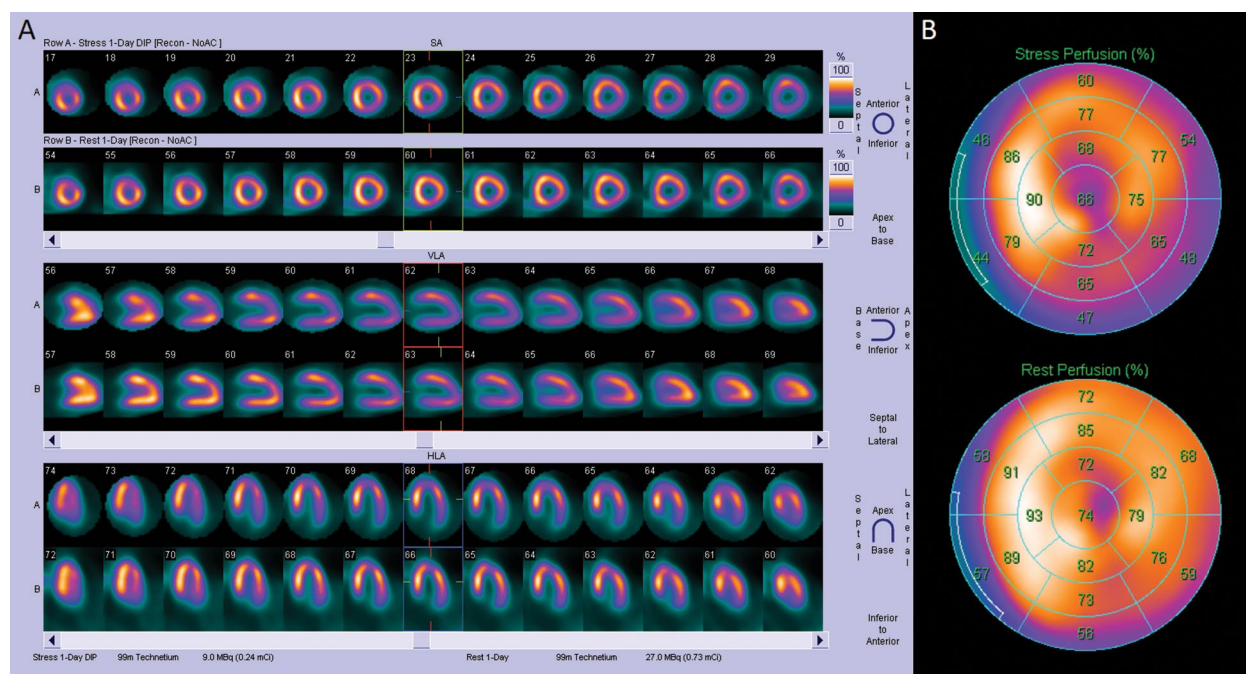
Myocardial perfusion scintigraphy – single-photon emission computed tomography (SPECT): left ventricular (LV) slices (A), bull's eyes (polar maps; B). Inducible perfusion deficits in lateral and infero-lateral walls, and in anterior and antero-lateral walls, involving 14% of the total LV myocardium
